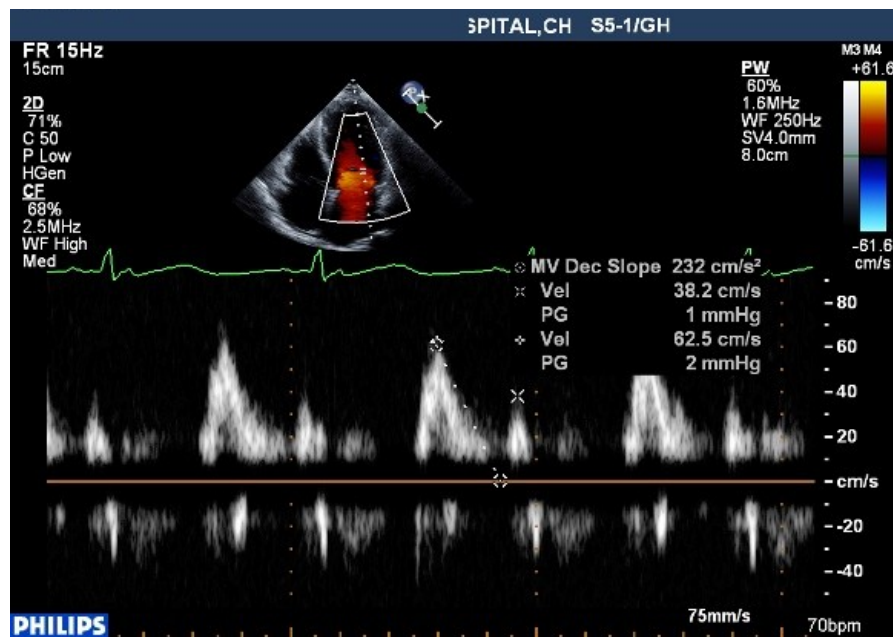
Pulsed wave Doppler echo of mitral inflow in a patient with AWMi
